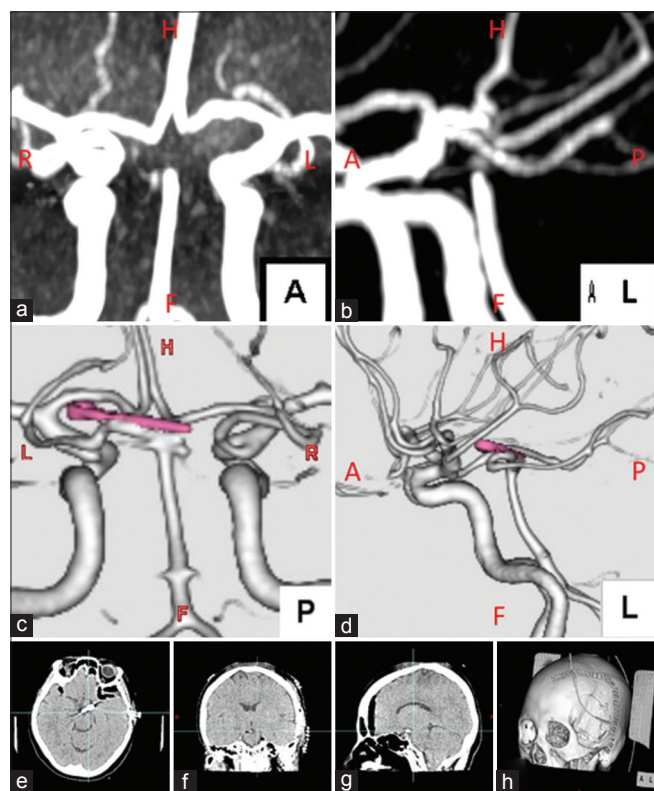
Postoperative imaging: (a) Anterior view of the magnetic resonance angiography showing no residual aneurysm; (b) Lateral view of the magnetic resonance angiography showing no residual aneurysm; (c) posterior view of the computed tomography angiography showing the position of the aneurysmal clip with no residual aneurysm; (d) lateral view of the computed tomography angiography showing the position of the aneurysmal clip with no residual aneurysm; (e-h) axial, coronal, sagittal, and three-dimensional skull views of the postoperative computed tomography scan of the brain
